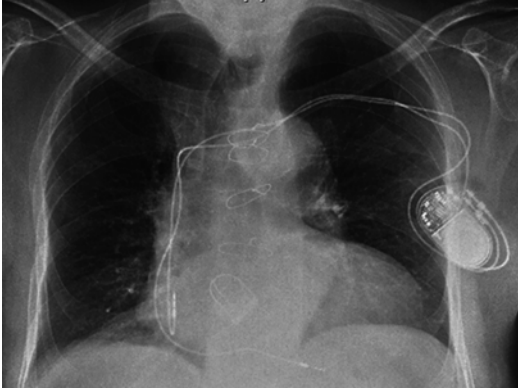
Chest X-ray showing normal cardiac and pulmonary dimensions, correct positioning of the pacemaker leads, and no complications related to the surgery procedure
